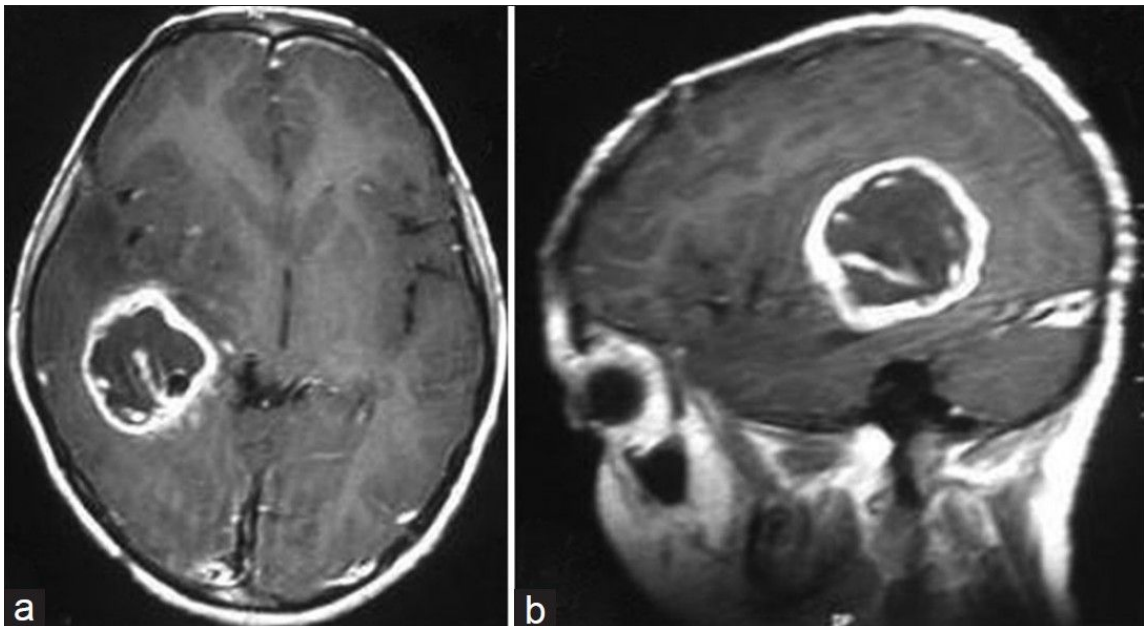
(Mahapatra, A., Borkar, S., Lakshmiprasad, G., Subbarao, K., & Sharma, M., 2013). Pediatric Glioblastoma Multiforme. High grade glioma with a high intensity division of tumor cells as seen in the CT scan.
